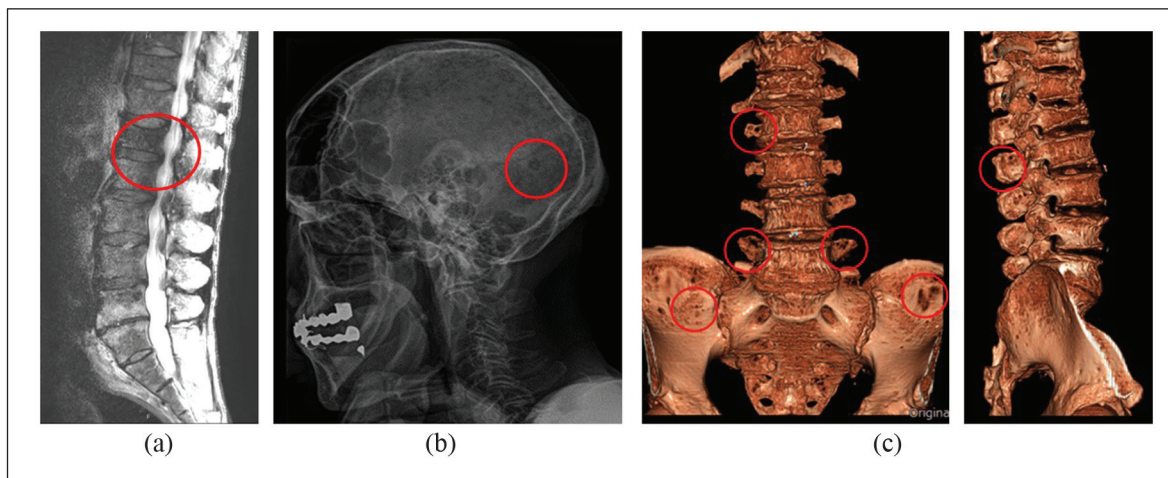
(a) Low LI signal on lumbar T1-weighted MRI and (b) punched-out lesion in the skull on cranial radiograph were observed (red circles). (c) Punched-out lesions in the transverse process and ilium on 3D CT of the lumbopelvic region were also recognized (red circles).
